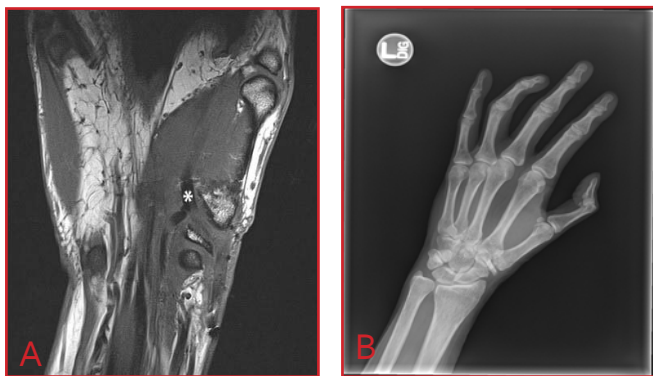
Results of imaging tests at 4 months postoperatively in case 2, showing acutely angulated flexor pollicis longus tethered at the site of operative treatment, with the interphalangeal joint held in a flexed position. (A) Magnetic resonance imaging showing angulated flexor pollicis longus (asterisk). (B) Radiograph showing anterior-posterior view.
